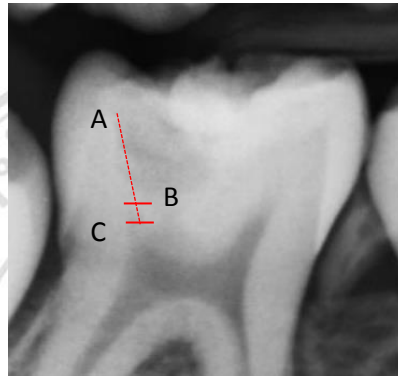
Deep dentin carious lesions are determined radiographically
